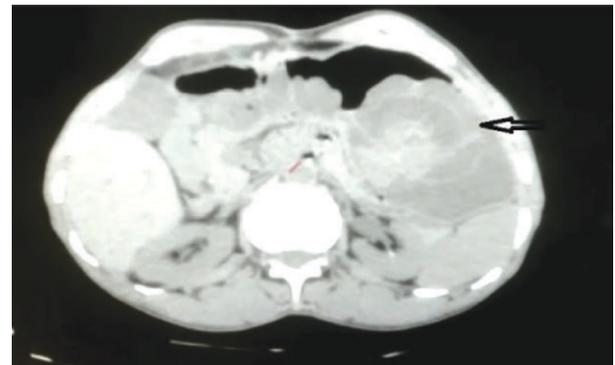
CT Abdomen image showing Jejunogastric intussusception
